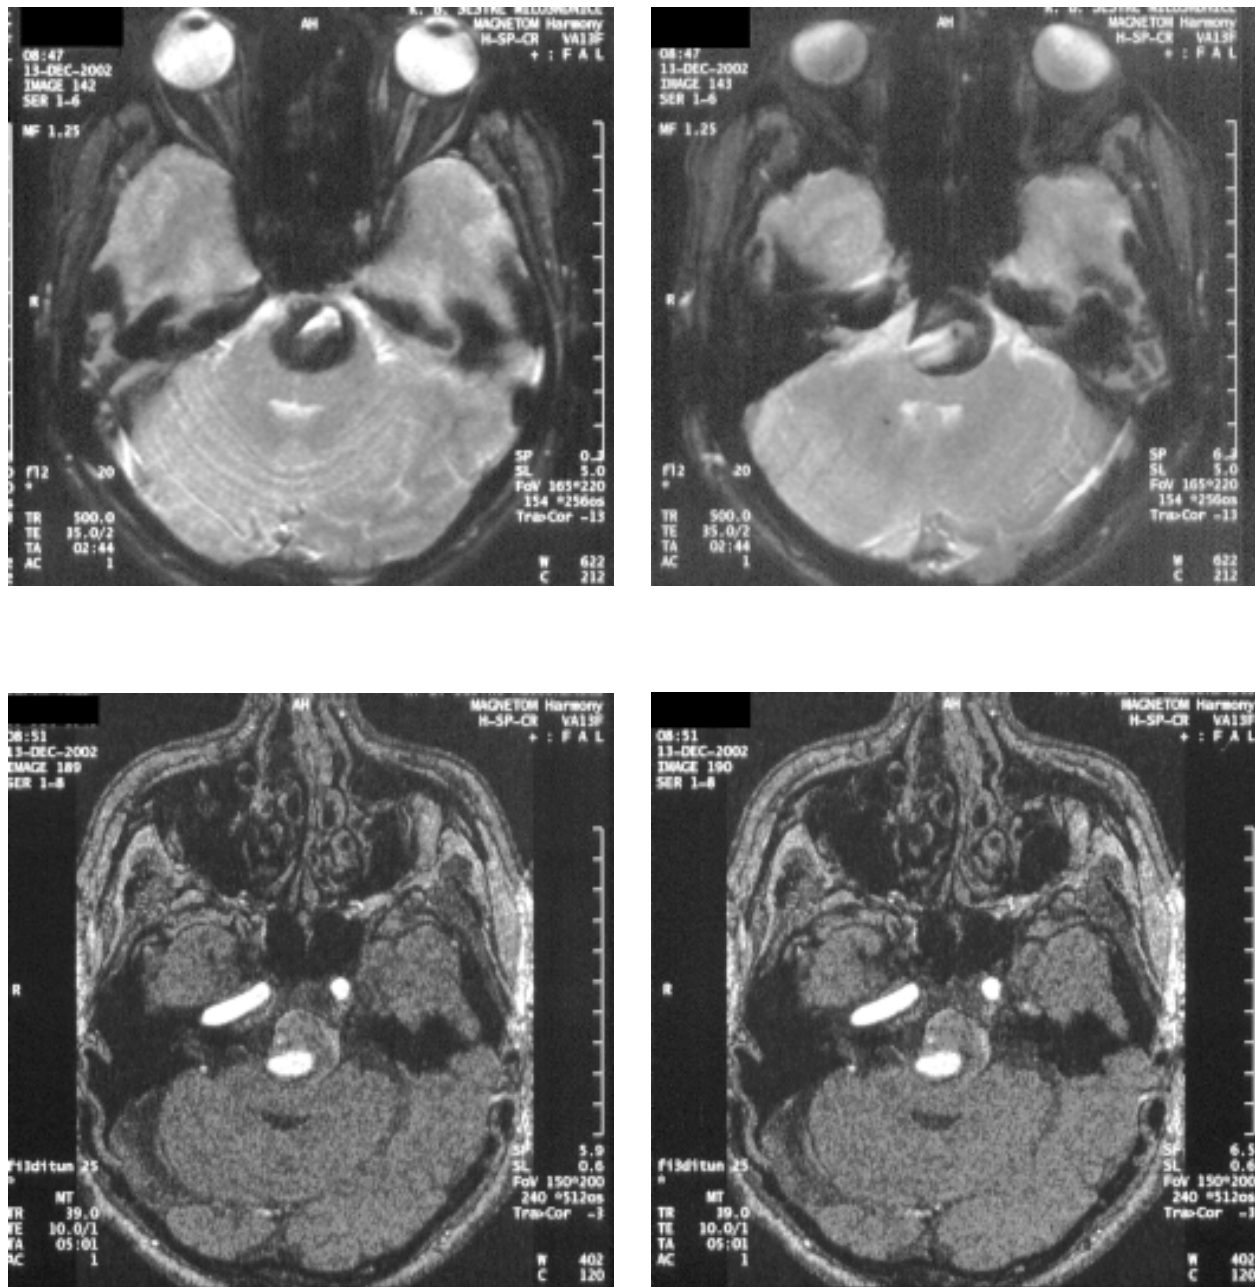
A 60-year-old male patient with left oculomotor nerve paresis and epistaxis: (a) and (b): transverse T2-weighted gradient-echo images; (c) and (d) 3D TOF MRA: gigant aneurysm of the basilar artery.*
